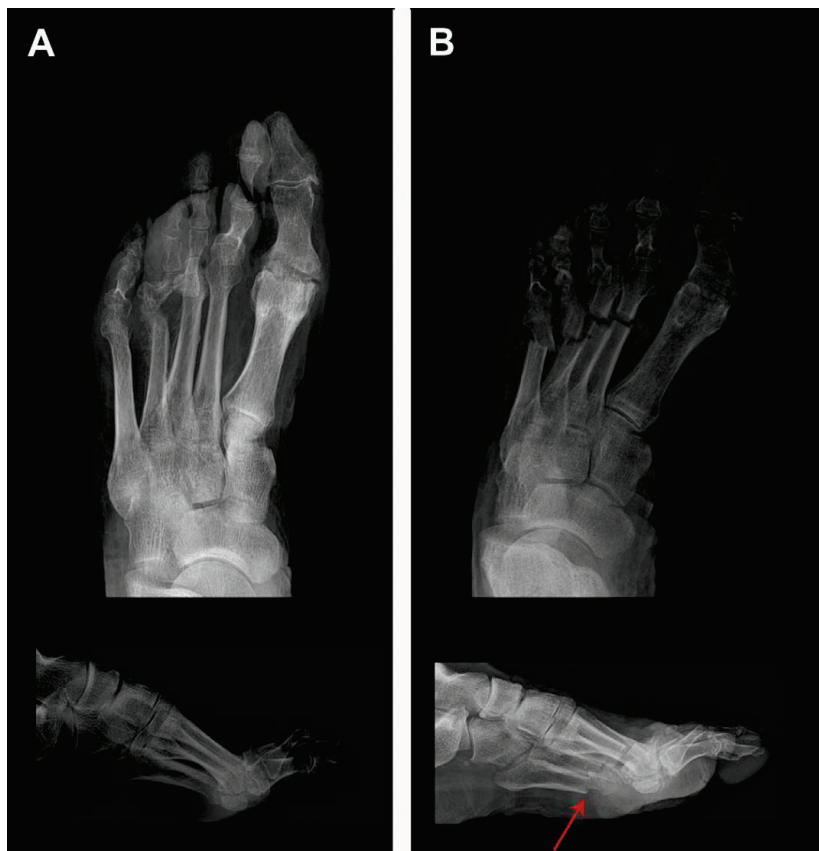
Case 5: radiographic images (left foot) at (A) preoperative, (B) 2-month, and (C) 6-month follow-up.
